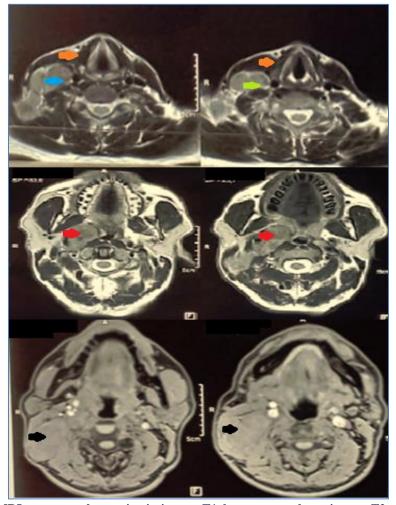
different MRI sequences showcasing isointense T1, heterogenous hyperintense T2 para and right retropharyngeal (red arrow) and jugulo-carotid (I, II, III, IV, V) (black arrow) and spinal adenopathies with repression of the internal jugular vein (blue arrow) and filling of the homolateral infratemporal fossa, retro and pre-styloid spaces and encompassing the right internal carotid (green arrow), with a normal size and morphology thyroid (orange arrow).
